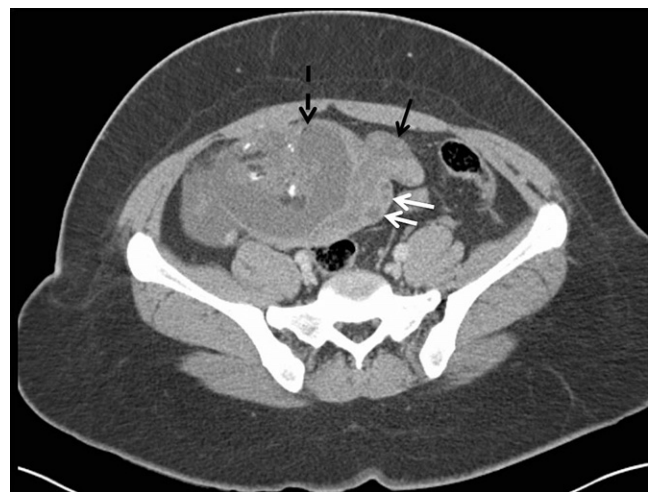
Left ovarian torsion related to a dermoid in a 23-year-old patient who presented with left lower quadrant pain. Axial contrast-enhanced computed tomography, revealing a 10-cm left ovarian mass that contains fat, soft tissue, and calcifications, which is diagnostic of a dermoid (black dashed arrow). There are multiple peripheral follicles (white arrows) in the left ovary. There is swelling of the left fallopian tube (black arrow), which may contain hemorrhage. There is associated right lower quadrant fluid as well as inflammatory changes of the fat adjacent to the left ovary.
